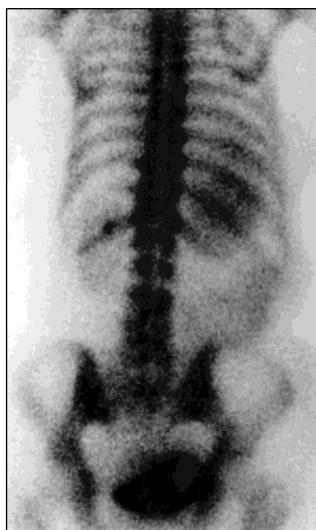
Posterior whole-body scintigraphic bone image acquired at the same examination as in Figure 1. There is a hot spot on the left 12th rib bone.
